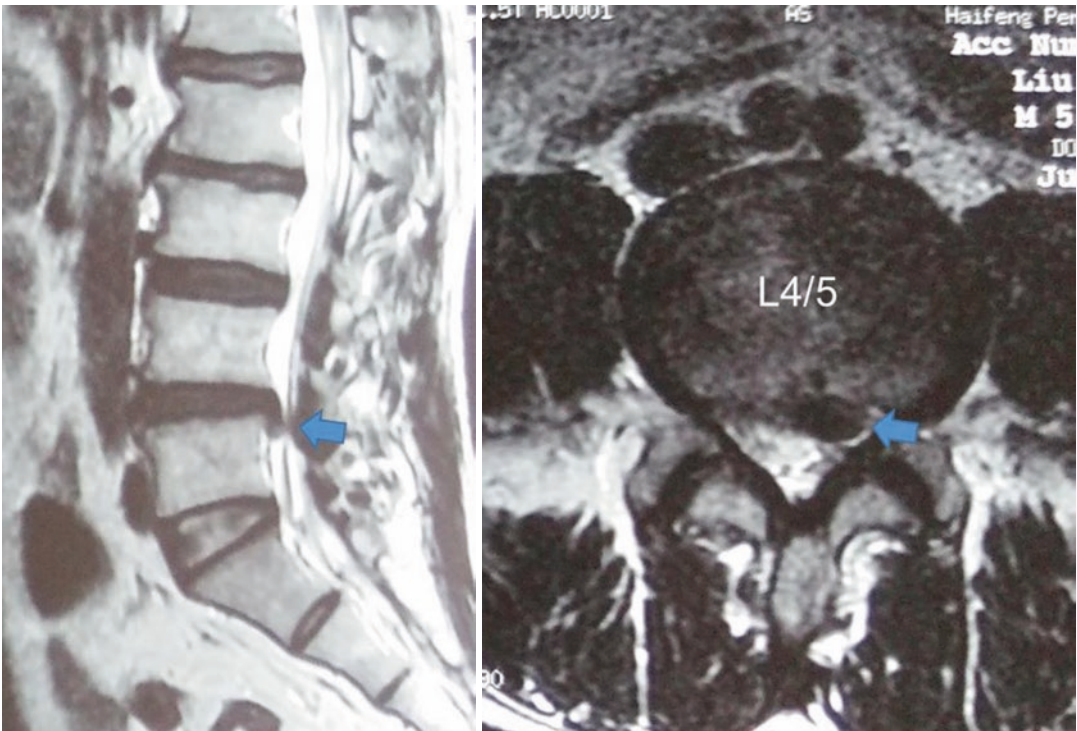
Preoperative MRI showed LDH on the L4-5 left side
